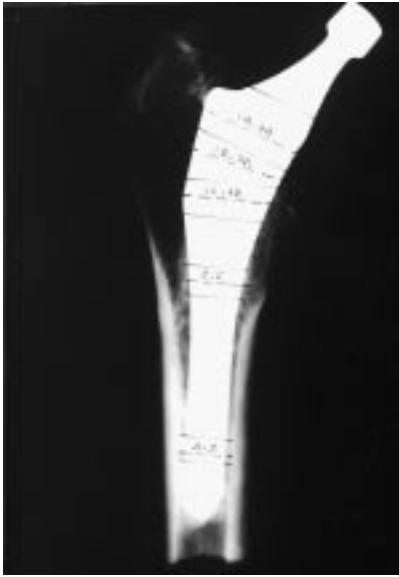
Postmortem radiograph of proximal femur showing osseointegration of the implant (see text) and the levels of the sections.
